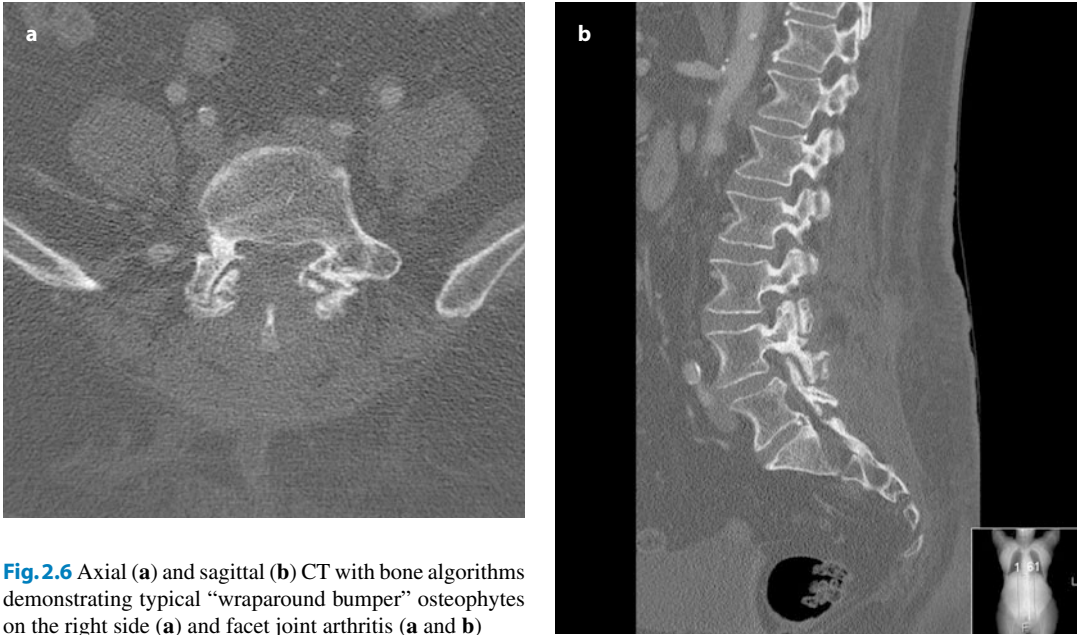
Axial (a) and sagittal (b) CT with bone algorithms demonstrating typical “wraparound bumper” osteophytes on the right side (a) and facet joint arthritis (a and b)
